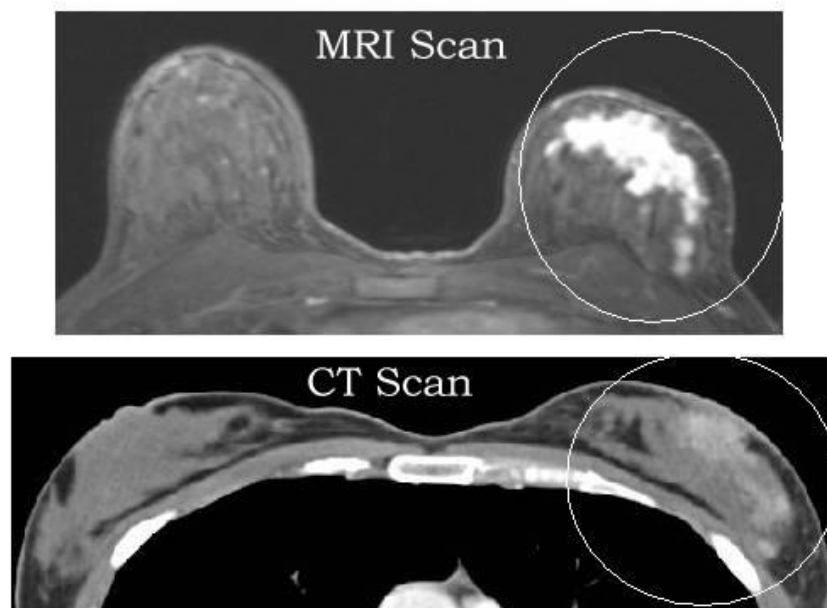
Comparison of MRI and CT images of palpable lesions (Robert J Miller, 2020b). These were taken on a patient with known cancer measured at 5.1cm after mastectomy. CT does not show this clearly, in contrast to MRI, although the mass was flagged as 'suspicious' during screening.
